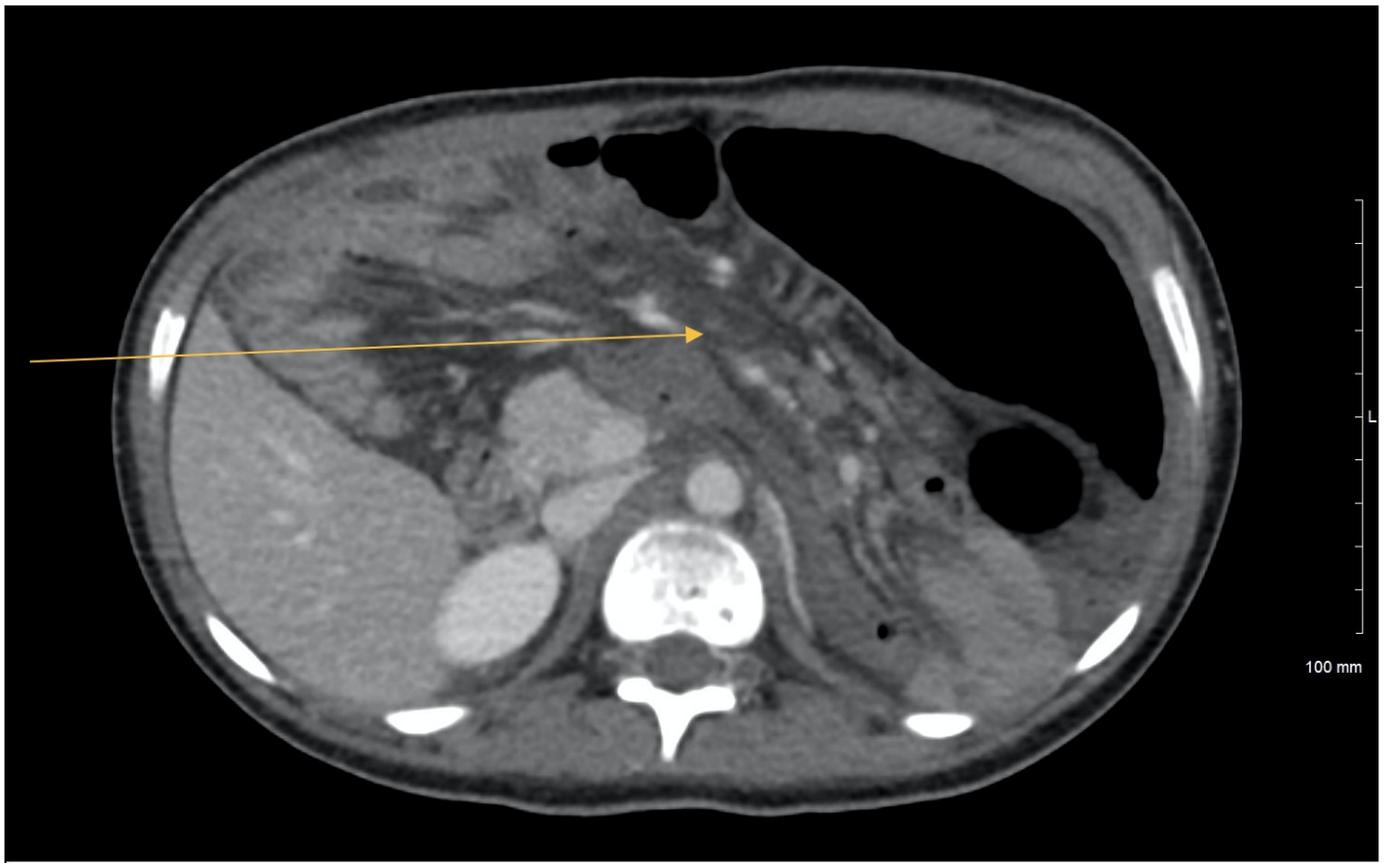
Computed tomography axial images showing herniation of mesenteric fat to right (yellow arrow).
